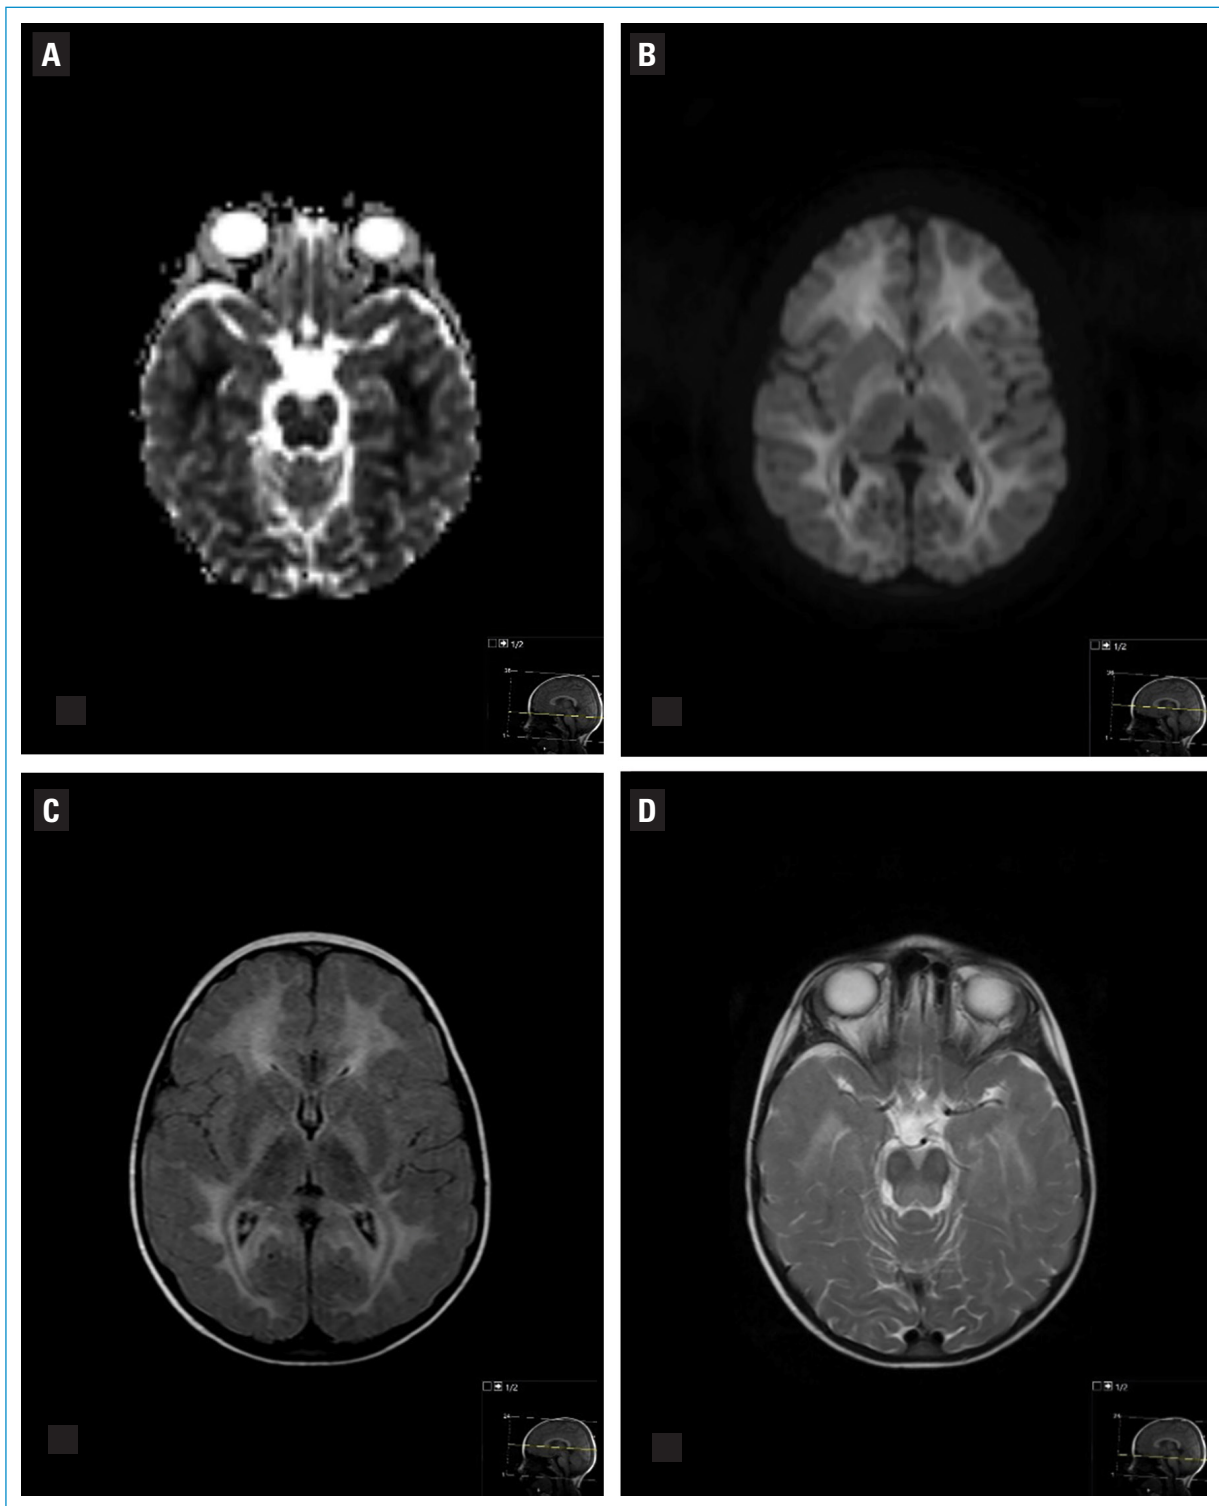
A-D: both MRIs showed diffuse restricted diffusion (high diffusion-weighted imaging (DWI) signal with a low apparent diffusion coefficient (ADC)) involving the bilateral cerebellar white matter, the dorsal part of the pons and brainstem, the dorsal limb of the internal capsule and the frontotemporoparietal white matter. There is also T2/FLAIR (fluid-attenuated inversion recovery) hyperintensity in the above-mentioned regions. The areas of restricted diffusion represent cytotoxic oedema. A: ADC, B: DWI, C: FLAIR, and D: T2.
